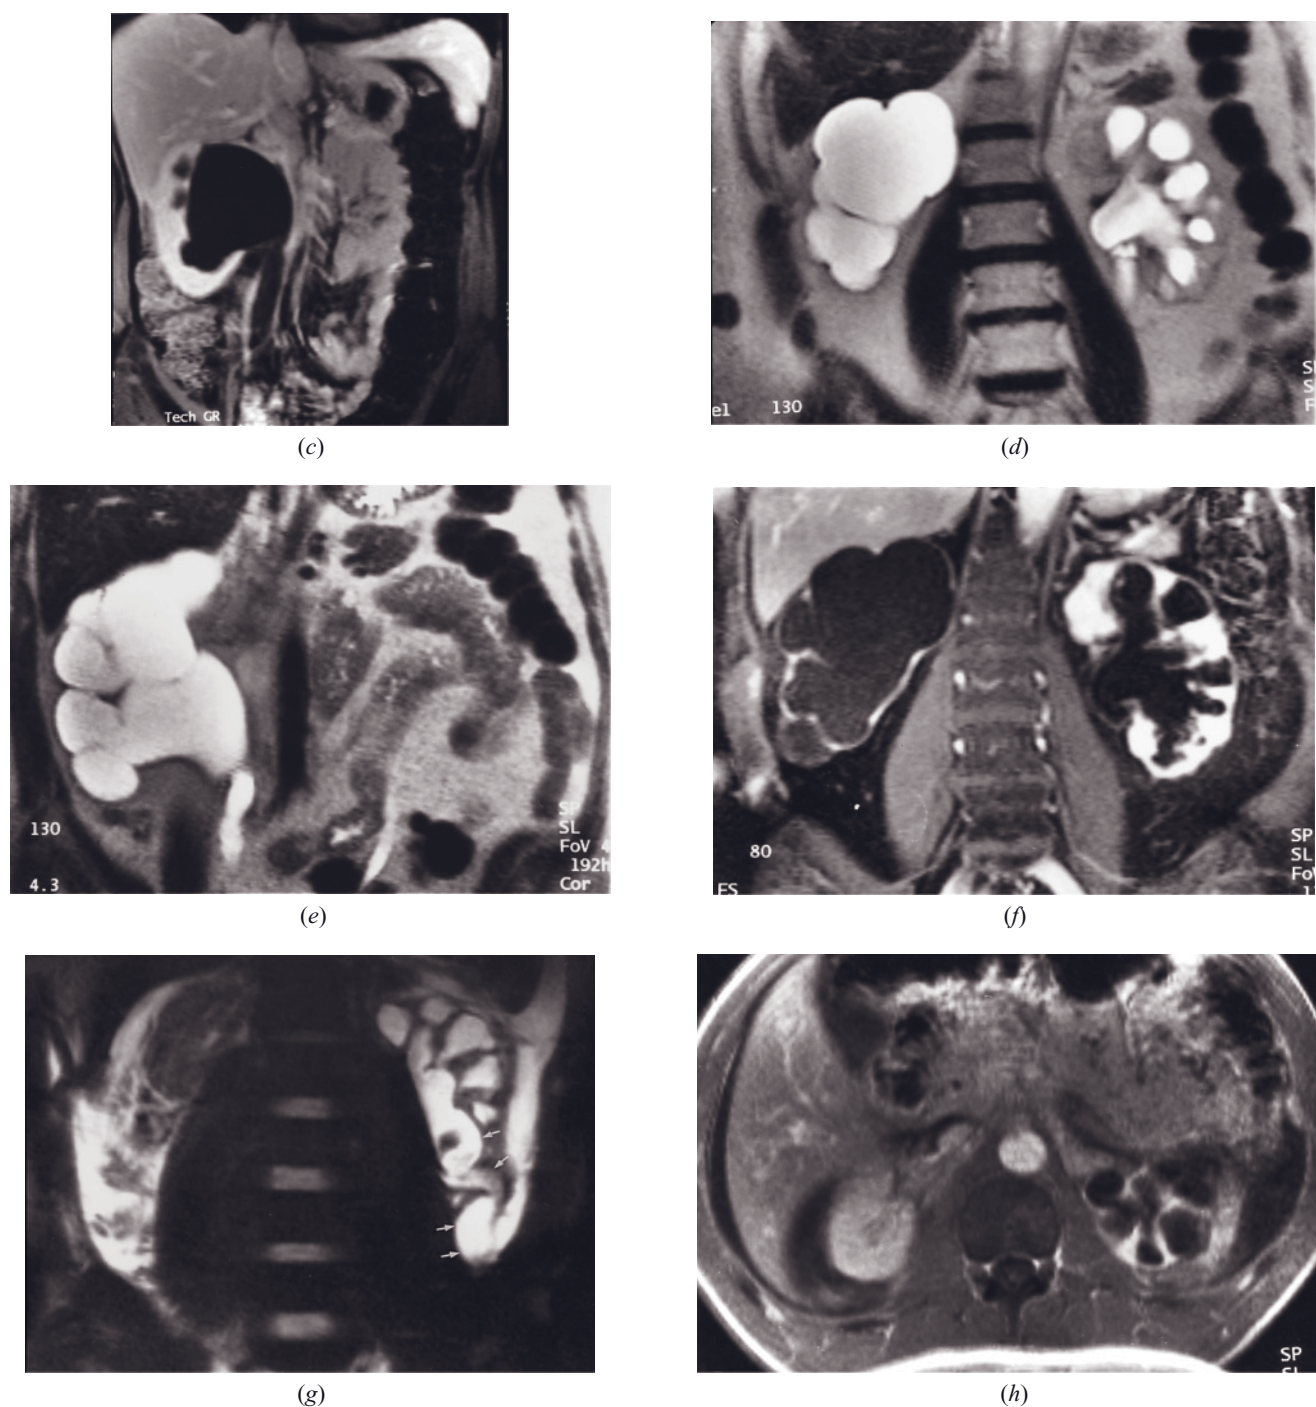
(Continued) gynecological malignancy. The coronal T2-weighted image (*a*) demonstrates the severe dilatation of the renal collecting system and ureter. The early-phase image (*b*) demonstrates diminished cortical enhancement of the obstructed right kidney compared to the left. The thickness of the renal cortex is well preserved. The late-phase image (*c*) demonstrates signal-void urine in the ureter and renal pelvis and enhanced renal cortex. Coronal T2-weighted SS-ETSE (*d, e*) and coronal 2-min fat-suppressed postgadolinium SGE (*f*) images in a second patient with bilateral distal ureteral obstruction. Massive hydronephrosis is present in the right renal collecting system, and severe dilatation is present in the left (*d, e*). After gadolinium administration (*f*), essentially no renal parenchyma is identified in the right kidney, whereas moderately severe thinning is present in the left kidney. Coronal T2-weighted SS-ETSE (*g*) and transverse T1-weighted 90-s fat-suppressed postgadolinium SGE (*h*) images in a third patient with longstanding ureterovesical obstruction secondary to childhood ureteric reimplantation. T2-weighted image (*g*) shows severe hydronephrosis and tortuosity of the ureter (small arrows, *g*) of the left kidney. The transverse gadolinium-enhanced image (*h*) demonstrates extreme thinning of the renal parenchyma in the left kidney, which is effectively nonfunctioning. A normal-appearing right kidney is seen. Intraperitoneal high signal intensity on the T2-weighted image and low signal intensity on the T1-weighted postgadolinium image represent ascites.
